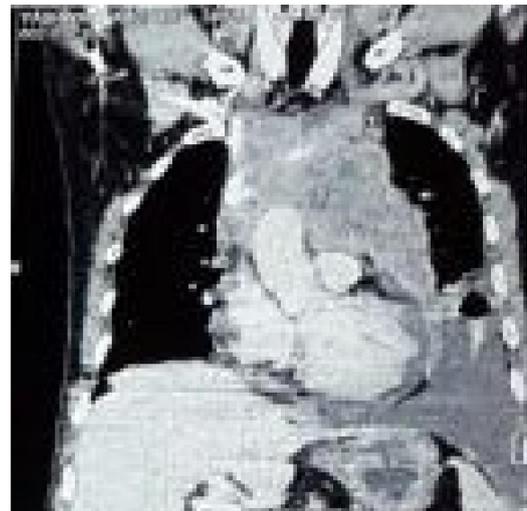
HRCT Chest sagittal section PA view showing anterior mediastinal mass with pleural effusion
